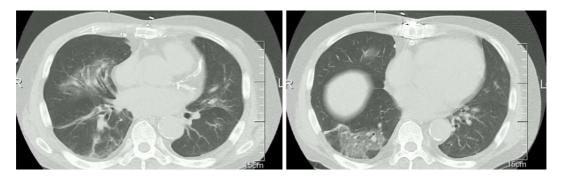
Chest computed tomography performed on disease day 13 shows ground-glass opacities in the right middle and lower lobes.
